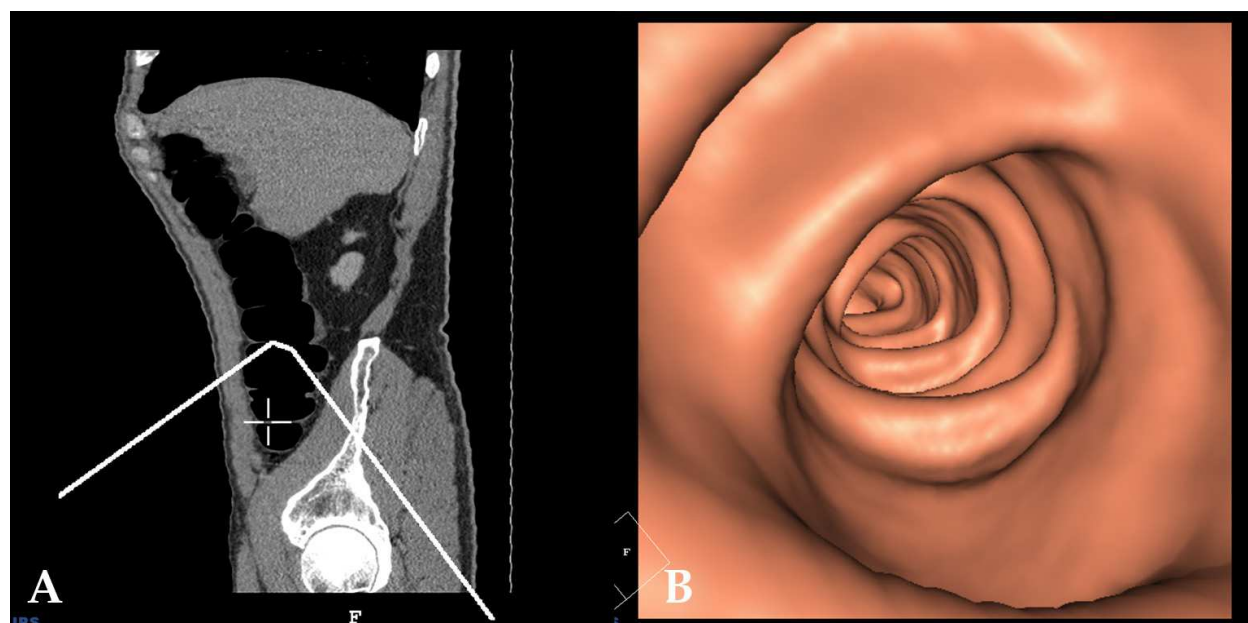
(A) 2D sagittal CT colonographic image and (B) 3D CT colonographic image show a normal smooth colonic wall.
